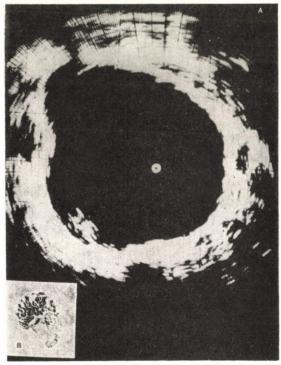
$U_1$  Intravesical ultrasonogram of a tumour of the size of a small bean on the right wall of the bladder. The bladder wall is intact, the tumour protrudes into the lumen. The waving echo-pattern shows the villous character of the tumour. B. pT<sub>1</sub>: Transitional cell carcinoma with papillary structure infiltrating into the submucosa
